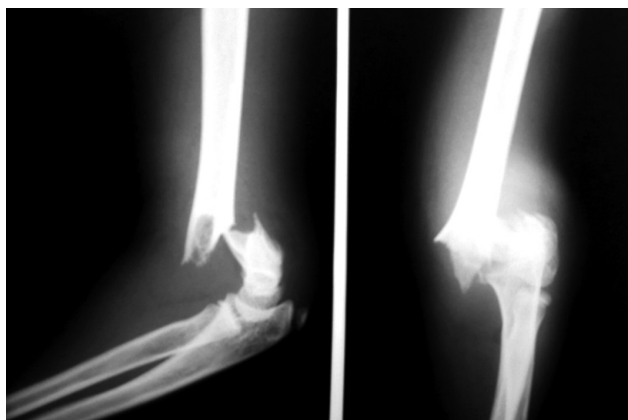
Pre-operative X-rays of elbow – AP and lateral views with displaced humerus fracture in children
